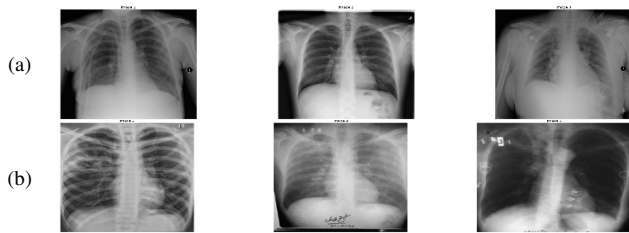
Sample chest X-ray images: (a) normal, (b) tuberculosis.
